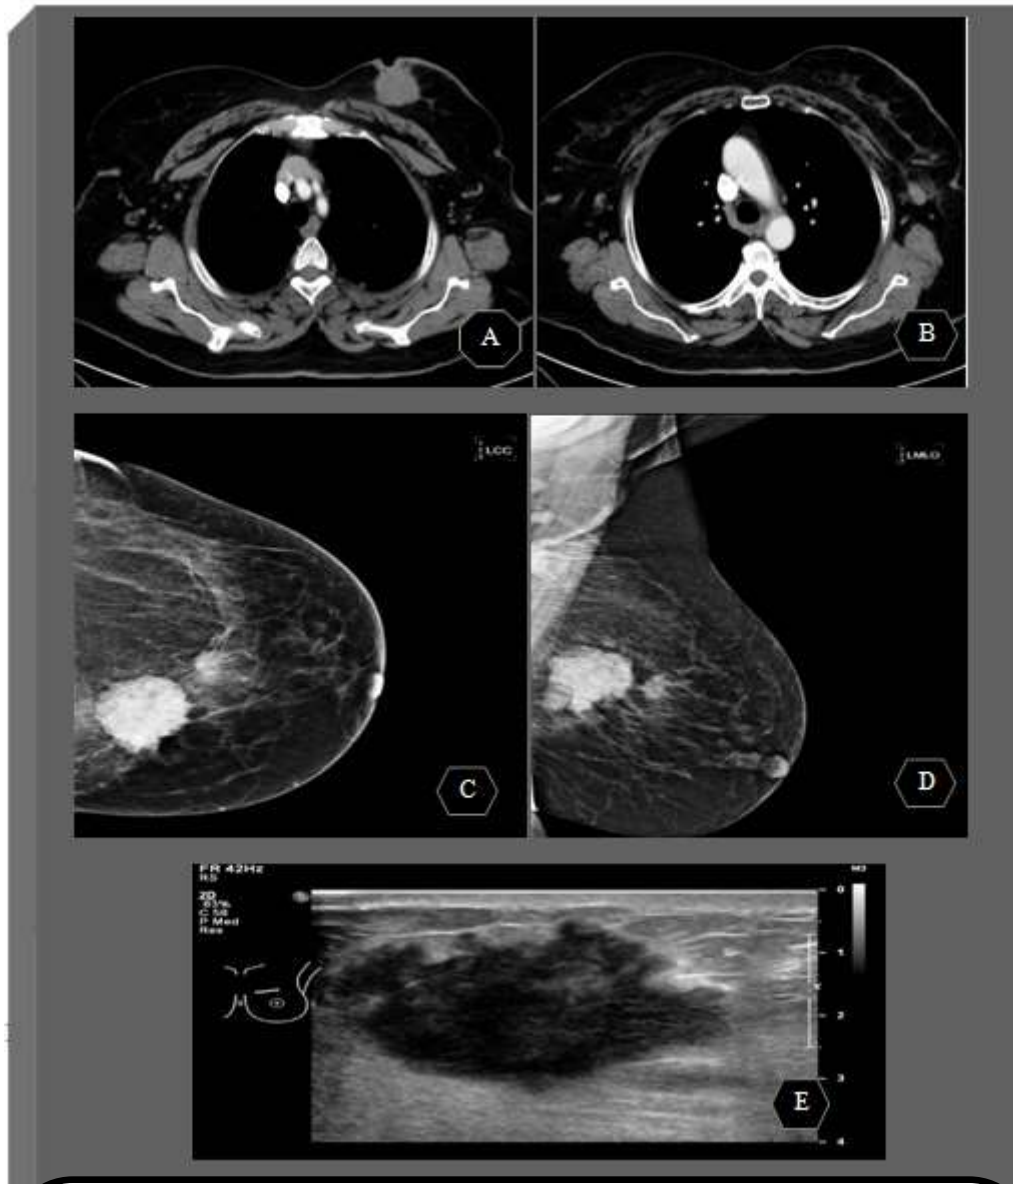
(A,B)axial reformatted images show soft tissue mass in left breast fungating to the skin associated with skin thickening and left axillary lymphnodes.(C,D) left mammography craniocaudal view[CC] and mediolateral view[MLO] shows an irregular mass in the mid inner aspect posteriorly measures 5.3 X4.8 cm with adjacent irregular mass measures 1.8 cm ,associated diffuse mild skin thickening .(E) breast Ultrasound shows an irregular hypoechoic mass in Lt breast upper inner quadrant[UIQ] highly suspicious.
